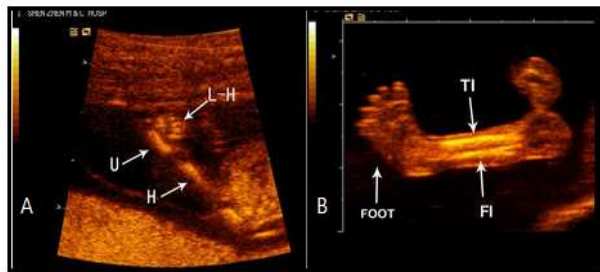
Transverse limb deficiencies (A: Absence of left radii and club hand. H, humerus; U, ulna; L-H, left hand; L-Leg, B; left leg high-resolution ultrasound imaging presenting T1 as tibia and F1 fibula having short bone length)
